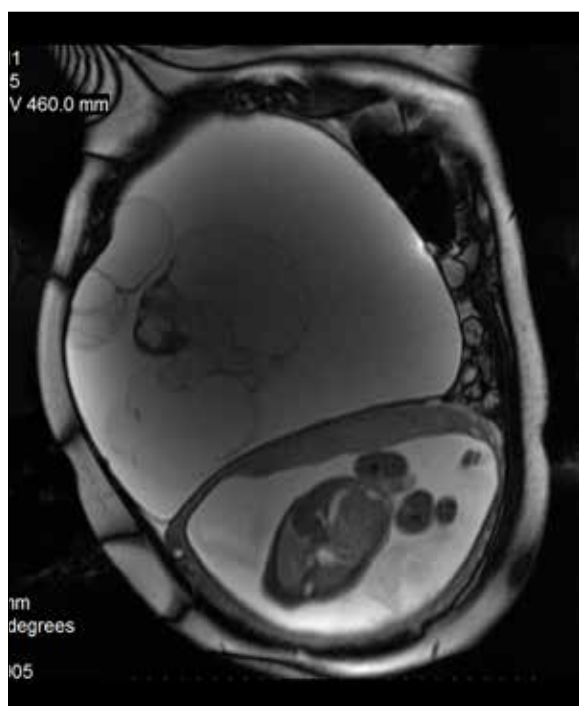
Endometrial ovarian cysts in a pregnant patient (week 16 of gestation) (A). In T1-weighted images, there is a strong signal similar to subcutaneous fat (B). After fat saturation, subcutaneous fat is suppressed and the signal of blood in the cysts remains strong (C). The patient was operated during pregnancy (week 16 of gestation).
